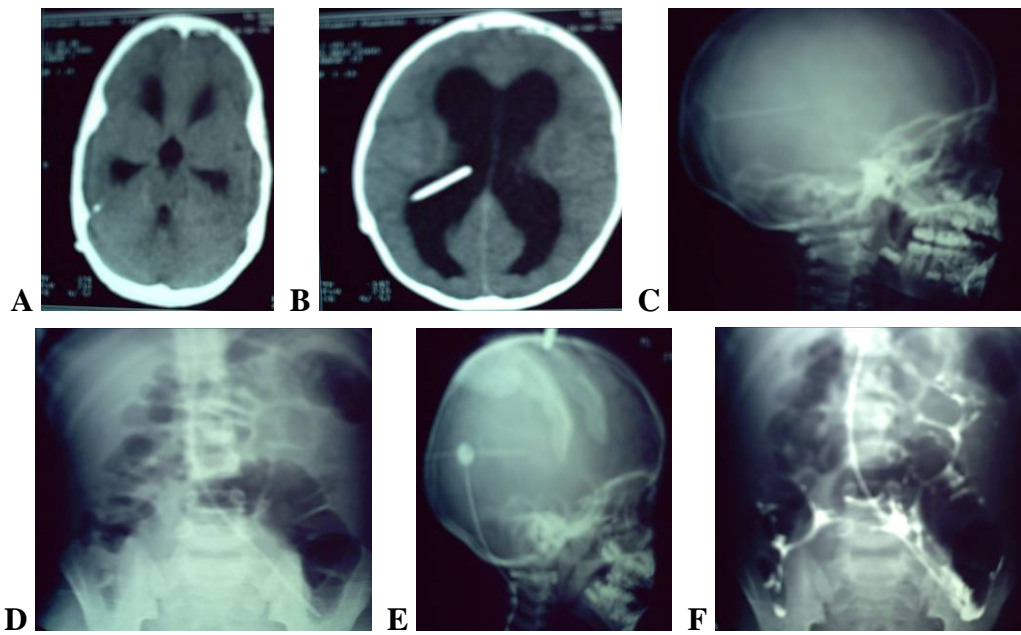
Case 19: male patient 7 yrs. old, CT brain revealed dilated ventricles. No CSF aspiration from reservoir, and radiographic shuntogram revealed free peritoneal spill of contrast material (proximal obstruction).
